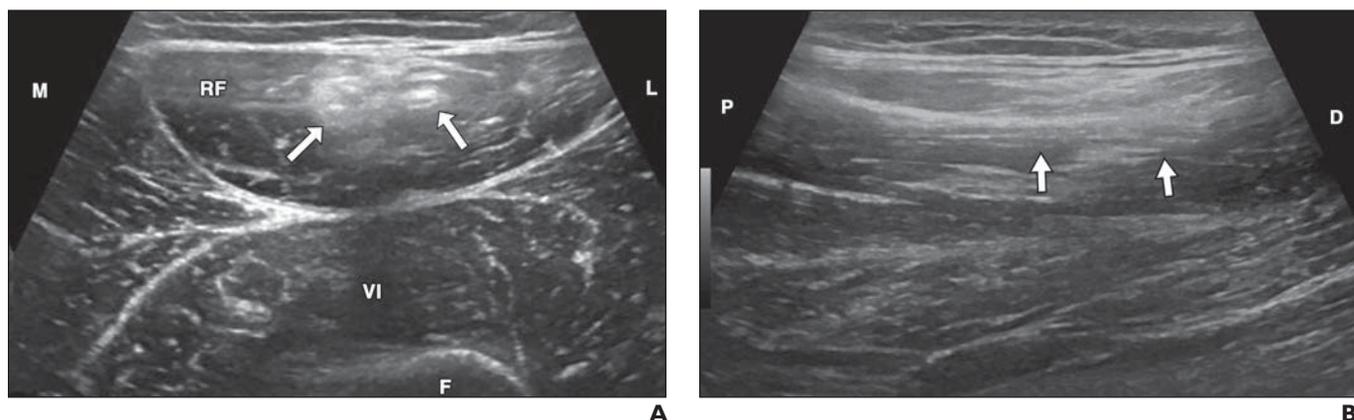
25-year-old man with prior right rectus femoris muscle tear. A and B, Transverse (A) and longitudinal (B) sonograms show increased echogenicity in central tendon with posterior acoustic shadowing consistent with remote tear and scarring (arrows). Note lack of fluid at site of scar consistent with remote injury. D = distal, F = femur, L = lateral, M = medial, P = proximal, RF = rectus femoris, VI = vastus intermedius.
